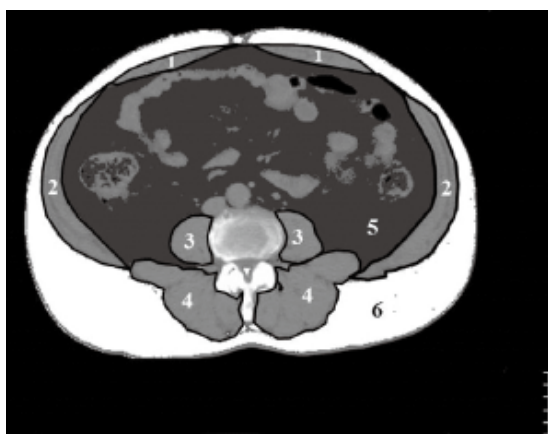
The CSAs of subcutaneous fat and abdominal skeletal muscles, i.e., the rectus abdominis 1, abdominal oblique 2, iliopsoas muscles 3, and erector spinae 4, were semi-automatically calculated by a well-trained measurer using CT images.
